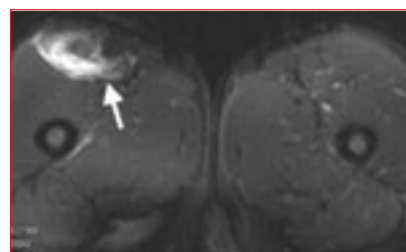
MRI of both quadriceps muscles showing grade 2 tear of right rectus femoris muscle.
